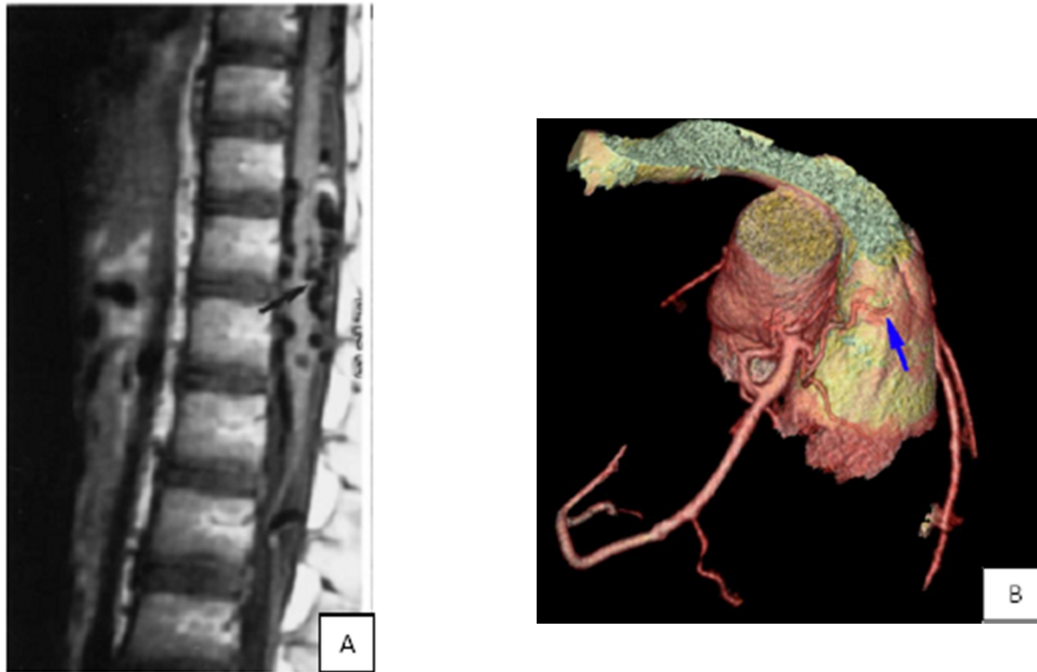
MR image shows enlarged blood vessels along the spinal cord conus (A) (Mandzia *et al.*, 1999) and a cardiovascular computed tomography (CCT) high resolution of a 34 year old female showing a malformation from the right coronary artery (RCA) into the pulmonary artery (B) (Khachatryan *et al.*, 2010).
